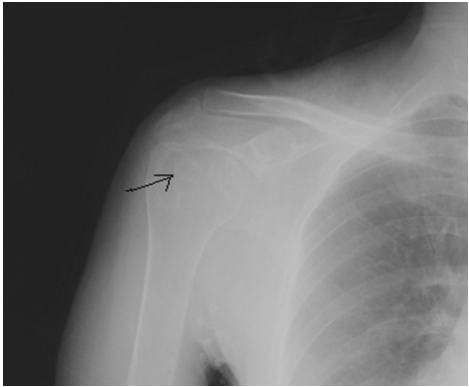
Hypodense areas shown in the plain radaigraphic X-RAY prior to the operation.
